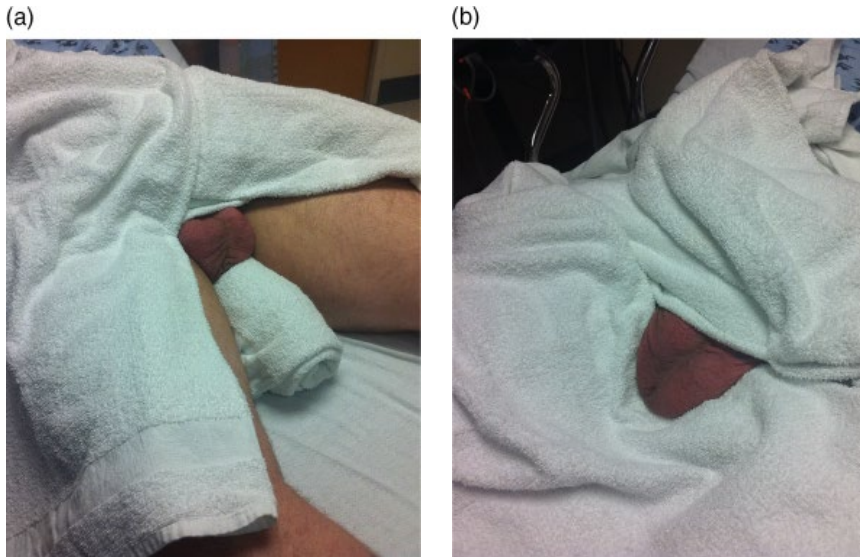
(a) A rolled towel placed between the thighs helps to elevate the scrotum. (b) An additional towel placed across the legs and beneath the scrotum further isolates the scrotum for ultrasound evaluation.
